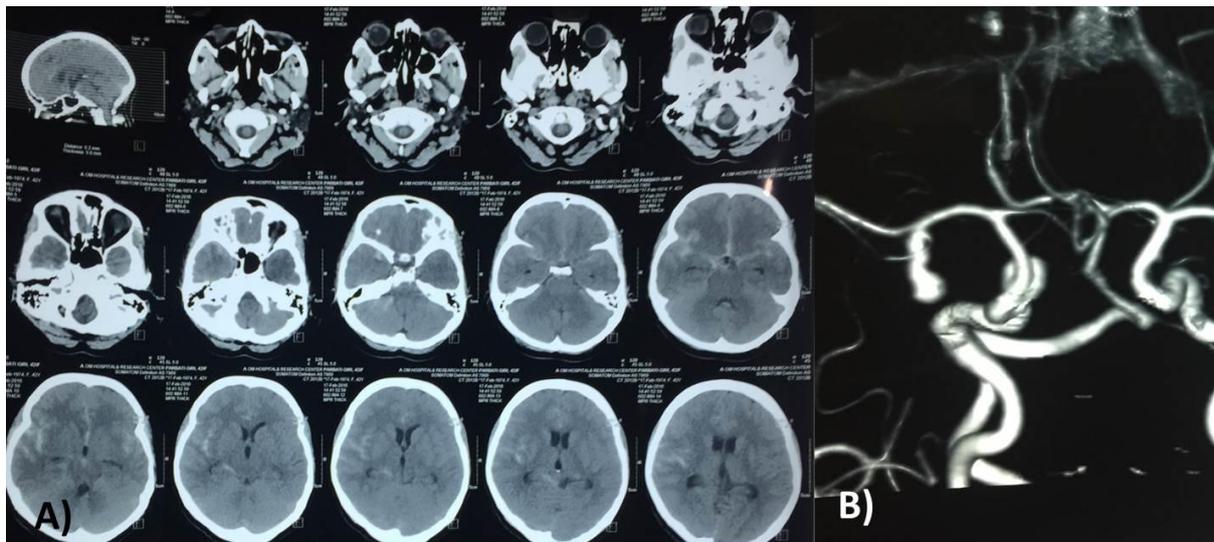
Preoperative images of the first aneurysm surgery case, A) pre-operative CT scan showing SAH more in the right sylvian fissure, B) CT angiography of brain showing elongated aneurysm in right MCA bifurcation
